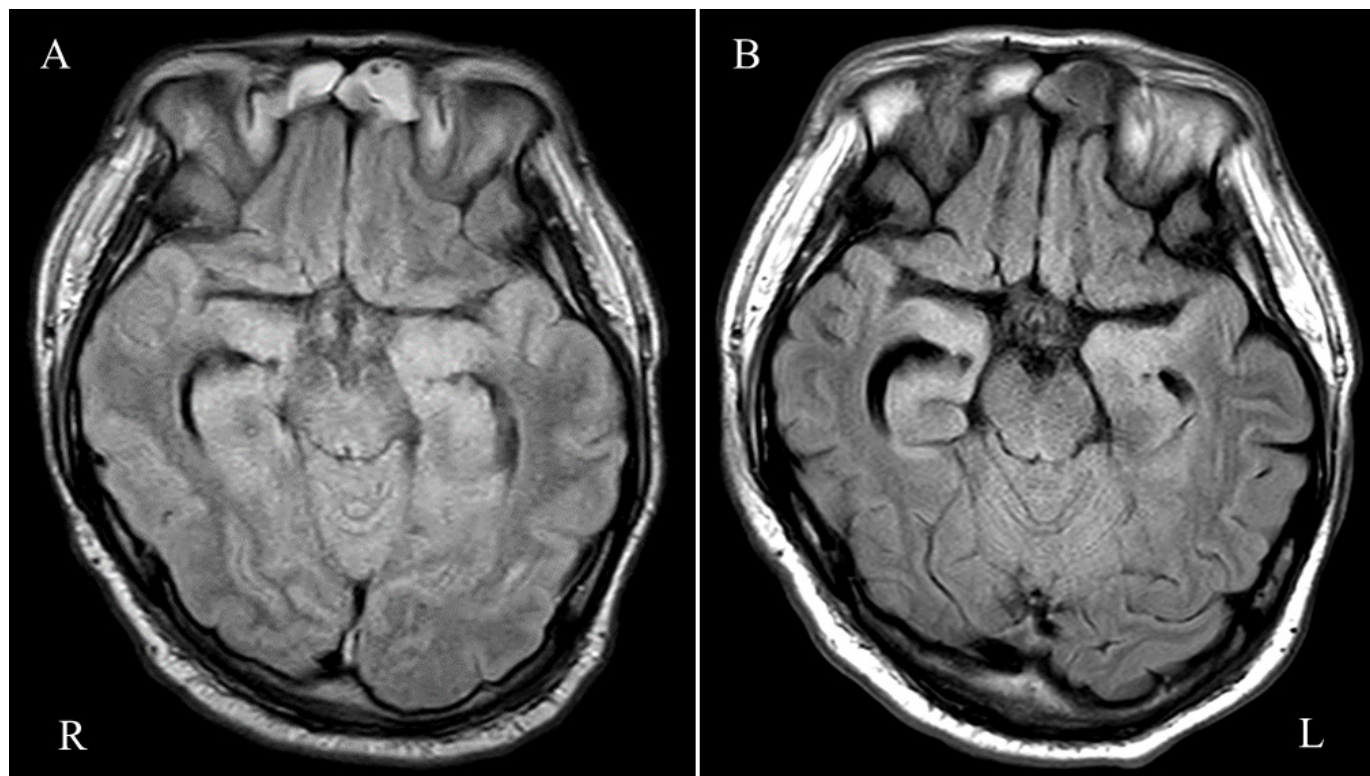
Time course of brain FLAIR-MRI results. MRI of the brain on day 3 showing a slightly high signal intensity bilaterally in the medial temporal lobes (A). Atrophy of the medial temporal lobe was conspicuous on day 57 after the identification of neurosyphilis concurrent with PSH (B). FLAIR, fluid-attenuated inversion recovery; PSH, paroxysmal sympathetic hyperactivity.
